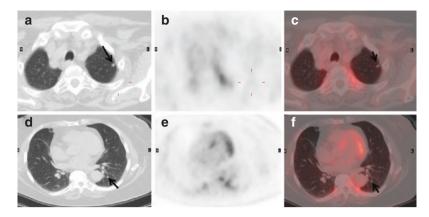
FDG PET-CT in suspected pulmonary metastases from colorectal cancer. 70-year-old male with caecal cancer and multiple tiny lung nodules 4-6 mm in size seen for example in the left upper lobe (arrow in a) and left lower lobe (arrow in d) on the axial CT sections. There was no corresponding FDG uptake on the fused images (arrows in c and f). This is likely due to the small size of the nodules which is below the resolution of routine FDG PET-CT (<7 mm). Based on the typical CT appearances these nodules should be considered suspicious for metastases even though not FDG avid
